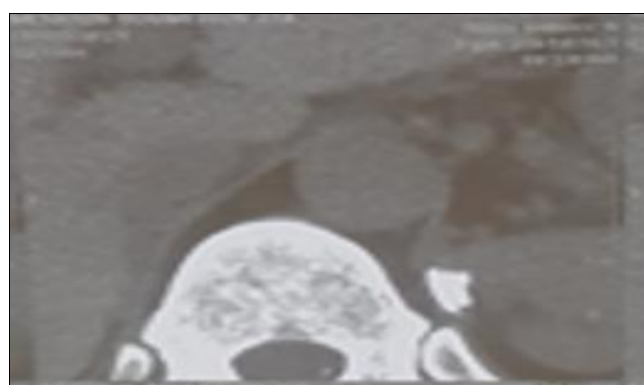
Abdominal CT scan showing bilateral adrenal calcifications. Axial CT image demonstrates calcifications of both adrenal glands (arrows), a radiological clue suggestive of adrenal amyloidosis in this context
